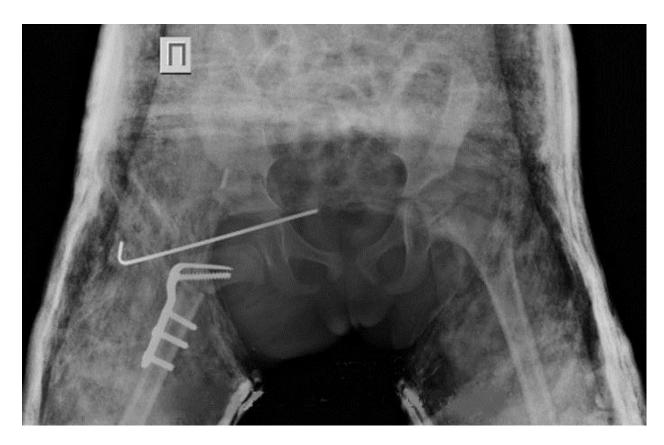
Patient B., 3 years and 6 months. Radiography in direct projection. Result one month after surgery (Patient in a plaster cast).
